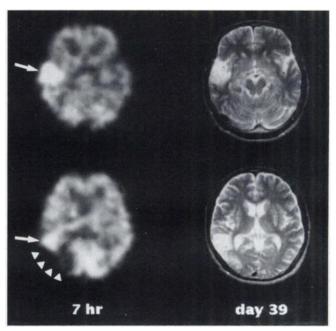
A 71-yr-old man with sudden onset of left hemiparesis and hyperesthesia. Hyperperfused (arrow) and hypoperfused areas (arrowhear's) on [123 I]IMP SPECT CBF images obtained 7 hr after onset (left column) are consistent with completely infarcted areas on follow-up T2-weighted MR images obtained in the chronic stage of infarction (Day 39, right column). All SPECT CBF images were registered and resliced after matching to follow-up CT.
